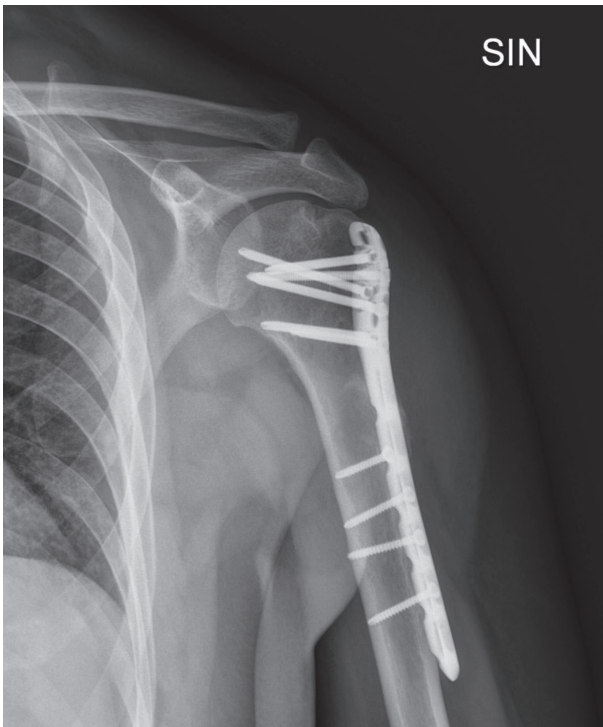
One year follow up x-ray.
